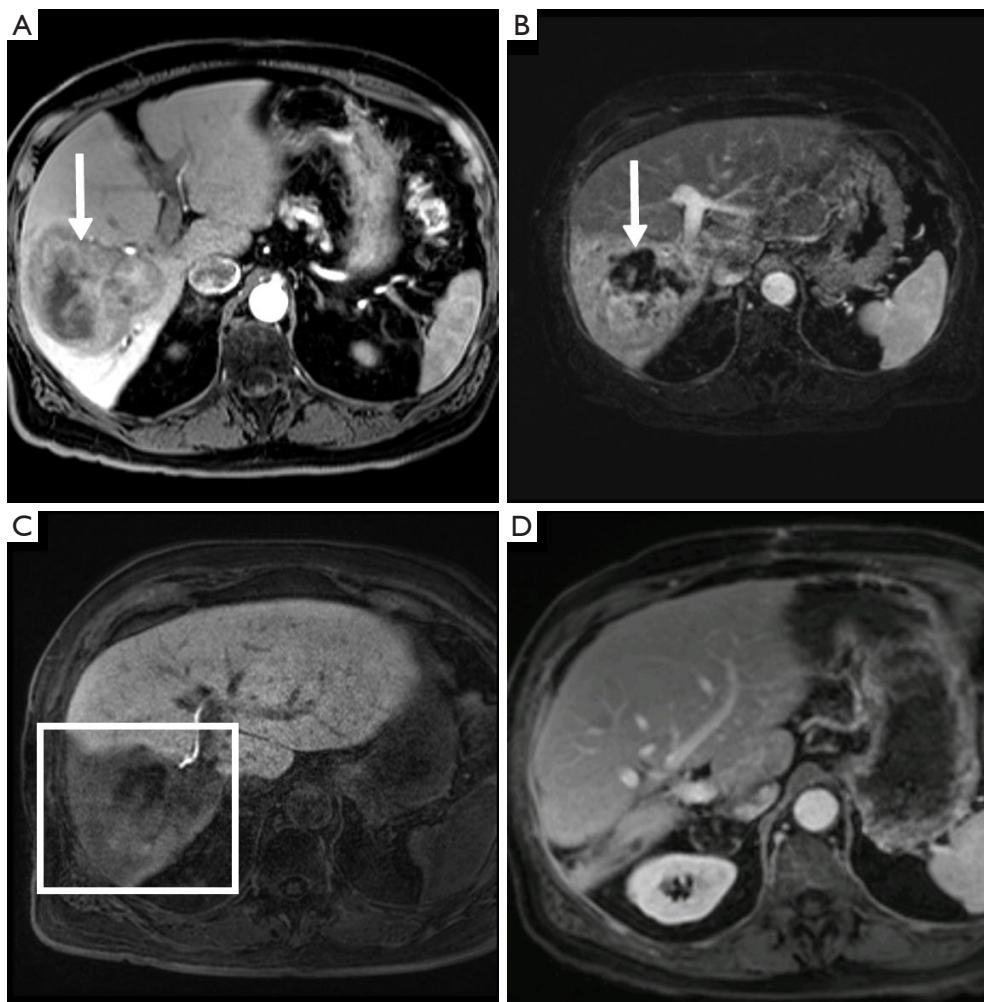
Post contrast MRI demonstrating a right lobe hepatocellular carcinoma (arrow) with a small FLR (A). Post hepatocyte contrast administration MRI obtained 6 months after initial TARE demonstrates tumor necrosis (arrow) (B), interval FLR hypertrophy, and poor excretory function of the FRS (square) (C). Post contrast MRI image obtained 14 months after resection demonstrates no tumor recurrence or evidence of liver failure (D). The patient remains free of recurrence 30 months after resection. FLR, future liver remnant; TARE, transarterial radioembolization; FRS, future resection site.
